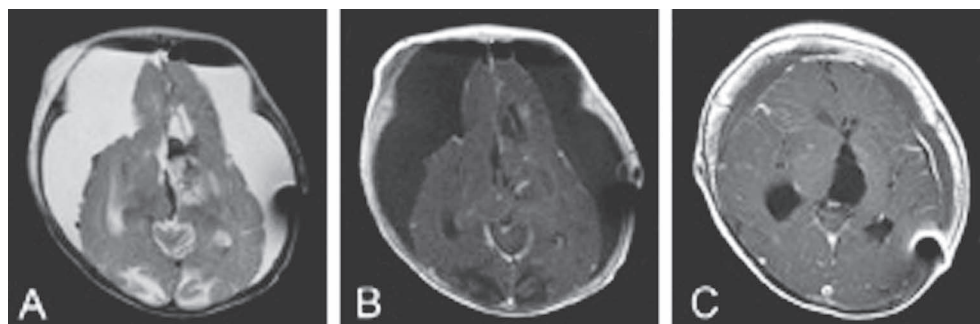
MR images after the last resection and 3 years after surgery. (A and B) Axial T2-weighted (A) and Gd-enhanced T1-weighted (B) MR images after the last surgical resection showing the small residual mass without enhancement. (C) Axial Gd-enhanced T1-weighted MR image 3 years after surgery showing the absence of enhancing lesions. Gd, gadolinium; MR, magnetic resonance.
